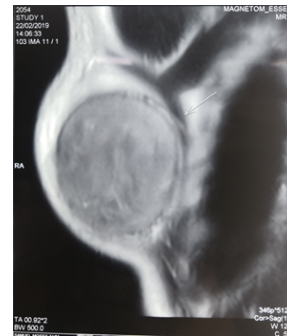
MRI of the swelling
